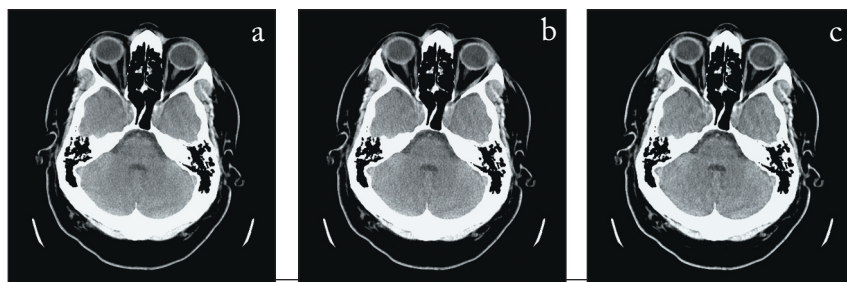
Neuro CT exam on a 41-year old male. (1a) Routine scan with no dose reduction; (1b) Same patient in 1a with 30% dose reduction; (1c) Same image in 1b processed with Sapheneia Clarity CT.
